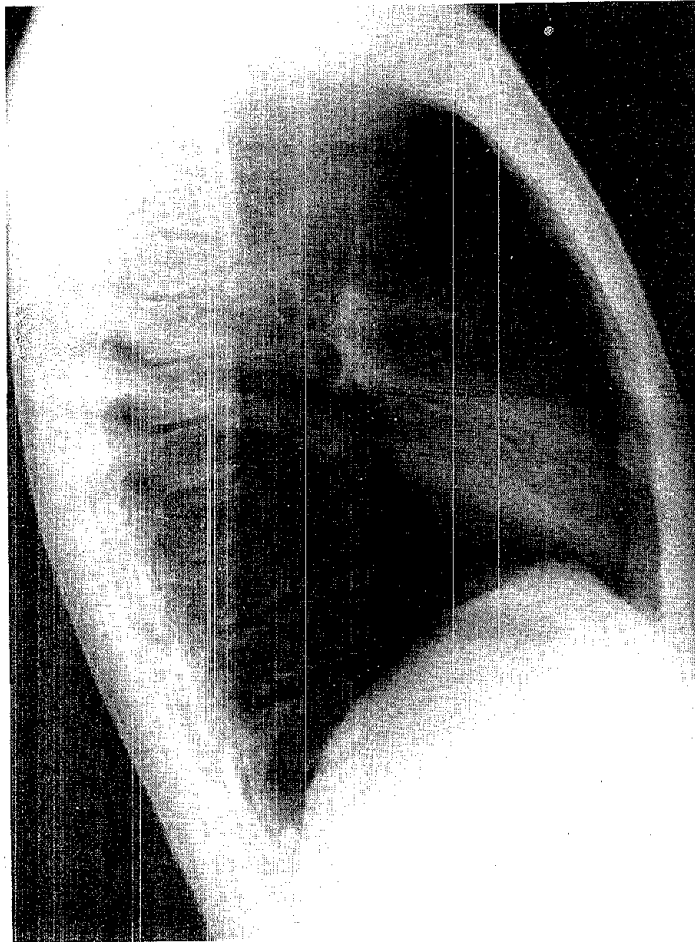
Lateral chest radiograph correctly positioned.
